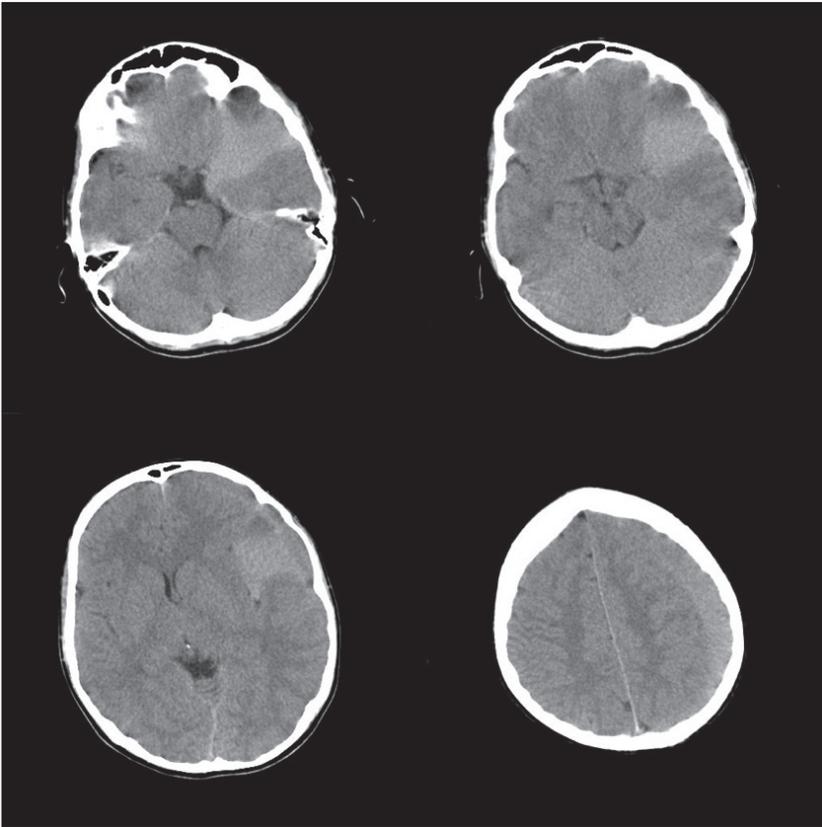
Preoperative CT scan images showing left temporal Sylvian intracystic haematoma of an arachnoid cyst and accompanying subacute subdural haematoma.
